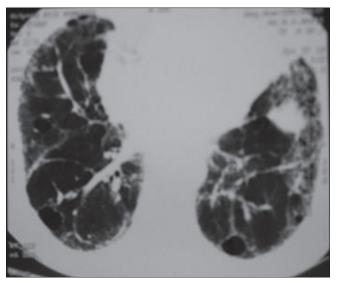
High-resolution computed tomography chest of case of idiopathic pulmonary fibrosis showing bilateral subpleural cysts and honeycombing with thickening of the central interstitium
